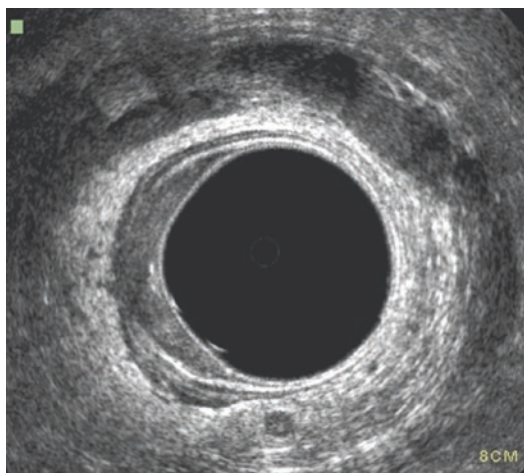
Endorectal ultrasound image demonstrating locally advanced rectal cancer
